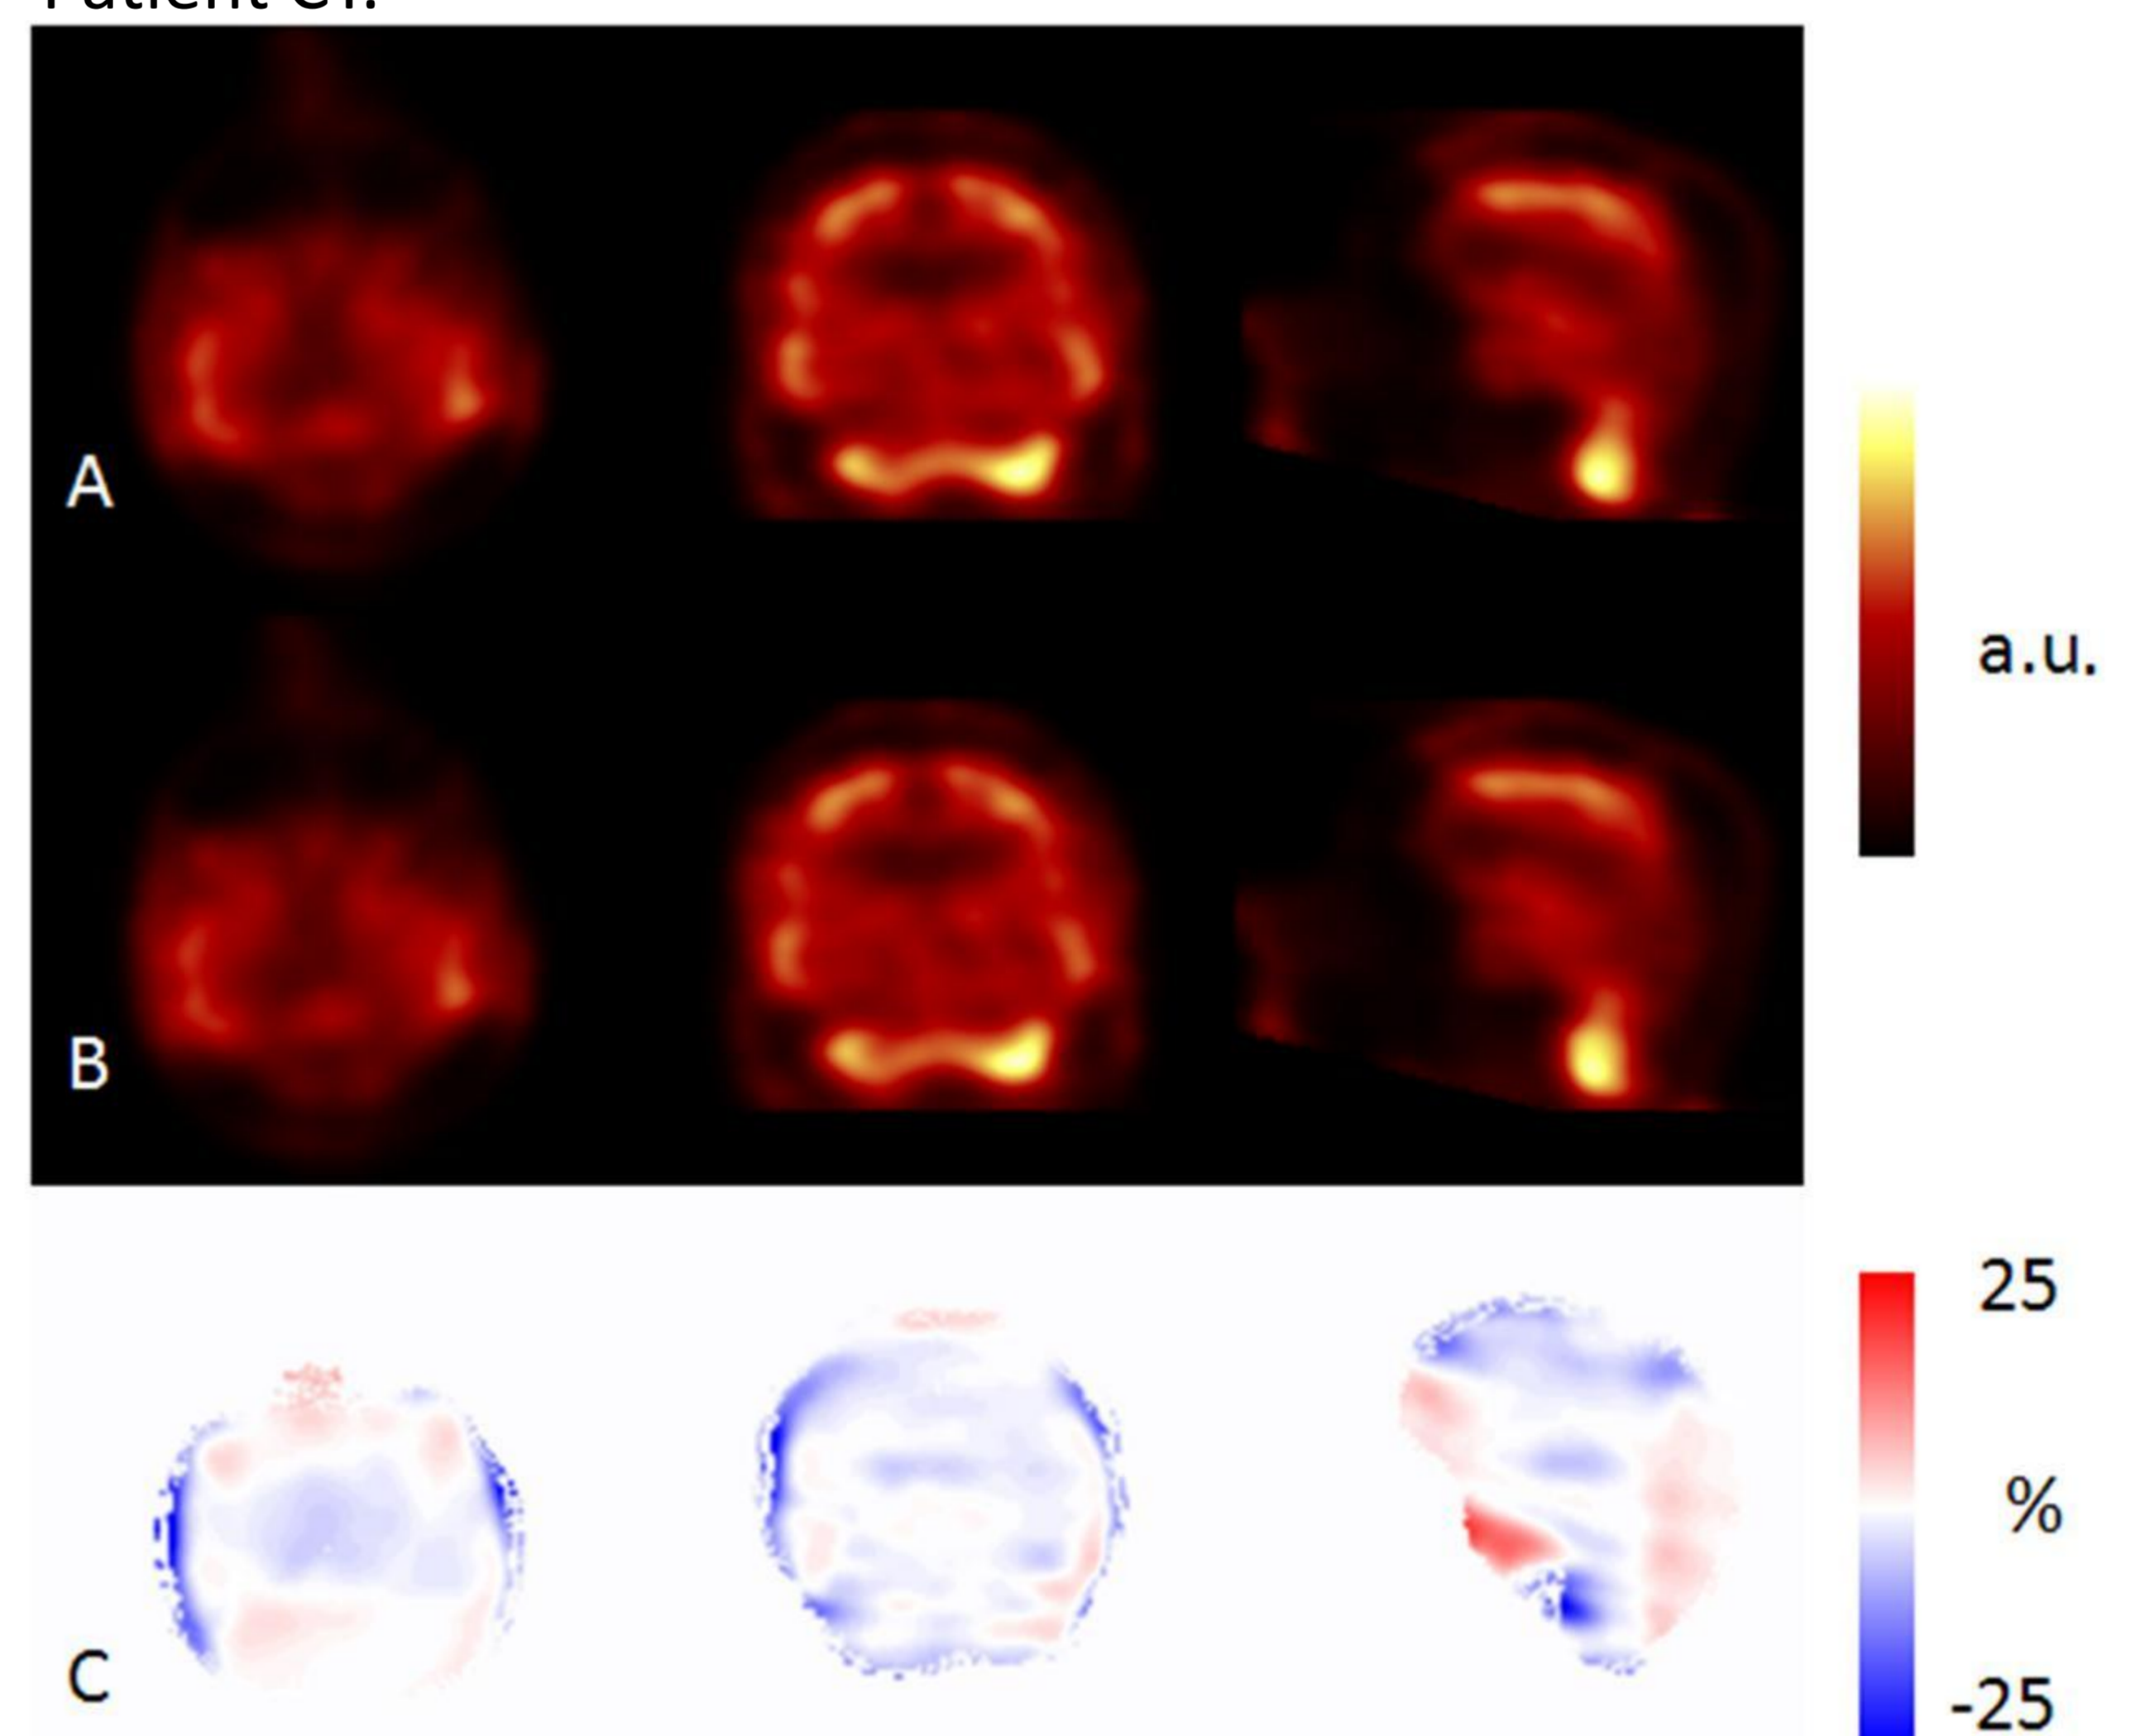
(A) $SPECT_{MRAC}$ (B) $SPECT_{CTAC}$ (C) Brain RD map.
